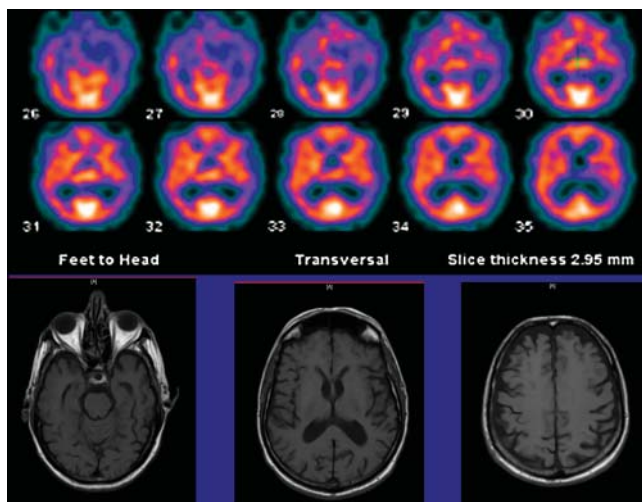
^{99m}Tc -ethylcystenatate dimer brain SPECT in the evaluation of dementia in a 74-year-old man. MR (bottom) indicated only mild cortical atrophy, whereas SPECT (top) showed severe hypoperfusion.
